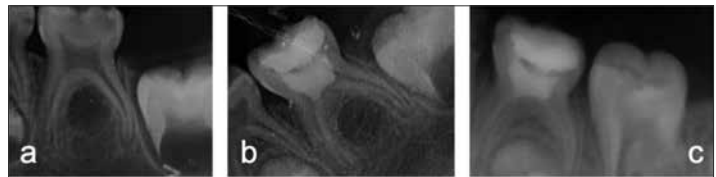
Radiographic appearance of case 1; a – preoperative; b – postoperative; c – postoperative 24-month follow-up
